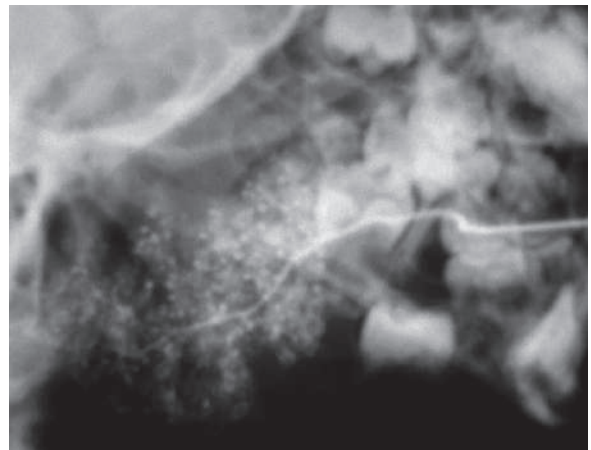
Lateral conventional sialography radiograph in a patient with submandibular sialectasia grade 1-2 seen as diffuse multiple punctuated dots between 1-2 mm in diameter
